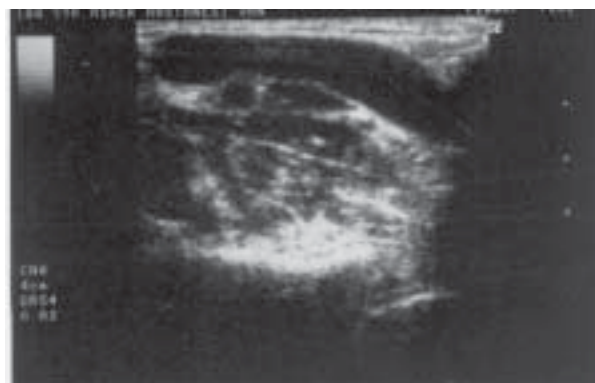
Venous ultrasonography reveals aneurismal dilatation of the external jugular vein.
